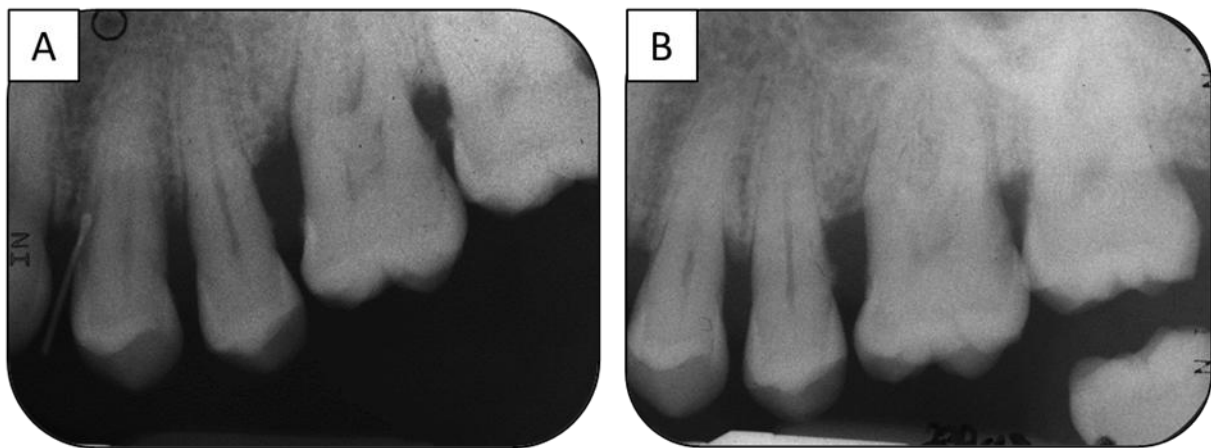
Radiography of region #24 to #26. A: Before periodontal therapy. Fistula tract region #24. B: 1 year after full mouth disinfection. Calculus at root surface #25 was removed afterwards
